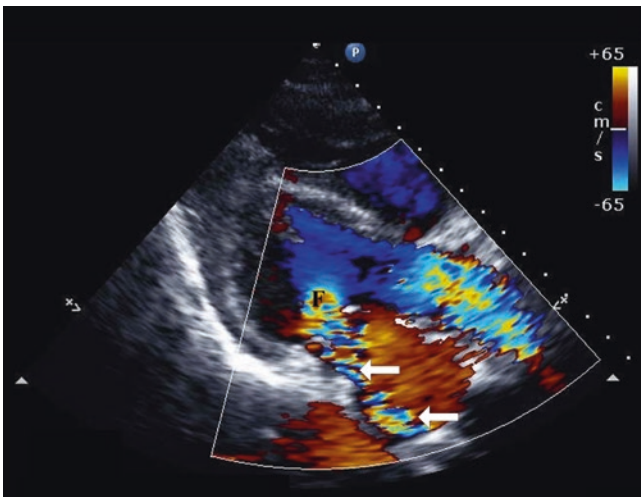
Infective endocarditis involving the mitral valve in a patient with shortness of breath and fever. Color Doppler echocardiography can identify mitral regurgitation and can help in gross estimation of the lesion severity. Careful attention must be paid to color Doppler settings such as Nyquist limit and color Doppler gain. In this patient, color Doppler demonstrates a jet of severe mitral regurgitation (*arrows*) with a large area of flow convergence (F). Quantitative assessment of the mitral regurgitation severity by the size of the regurgitant jet can be misleading and can result in both under- and overestimating lesion severity. Eccentric mitral regurgitation jets can have small jet areas and can be missed by the limited assessment using point of care ultrasound. Therefore, comprehensive echocardiography is required for accurate mitral regurgitation assessment and quantification. See also Video 20.5
